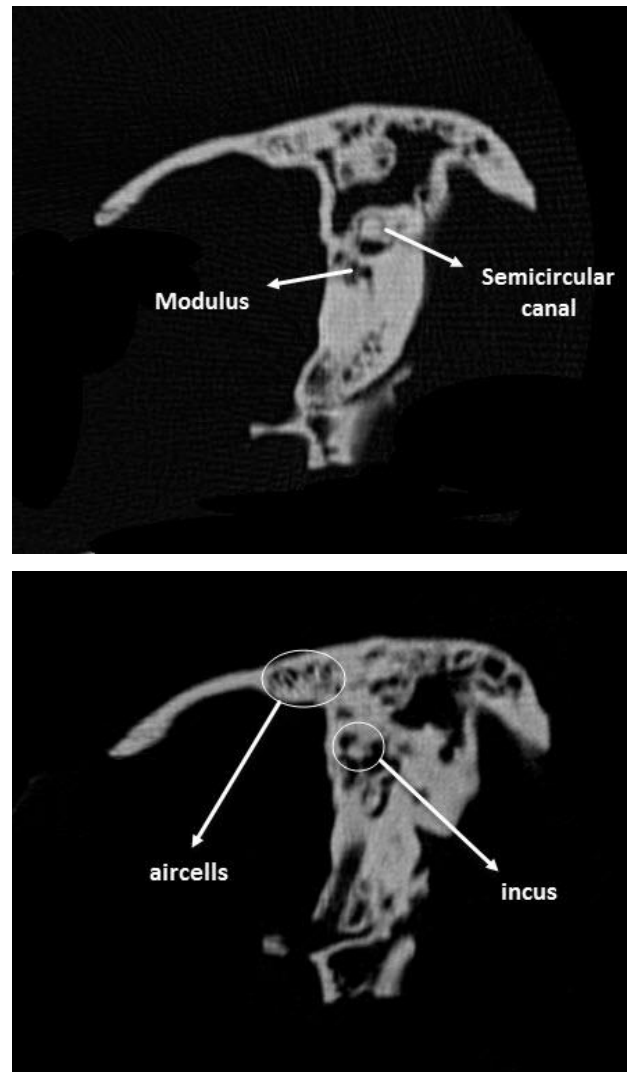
CT Scan of Artificial Temporal Bone (ABS).
